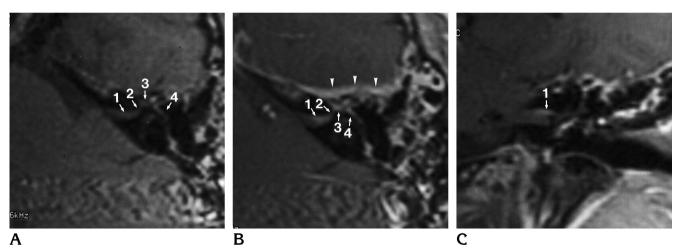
Noncontrast (500/15/2) (*A*) and contrast-enhanced (600/20/4) (*B*) transverse and coronal (*C*) T1-weighted MR images in a patient with delayed posttraumatic peripheral facial nerve palsy without associated fracture of the temporal bone, obtained 7 days after trauma, show moderate enhancement of the distal intrameatal segment (*1*) and minimal enhancement of the labyrinthine segment (*2*). The geniculate ganglion (*3*) and proximal tympanic segment (*4*) are normally enhanced. Intense dural enhancement is seen along the rostral border of the temporal bone, indicating possible microtrauma of both the temporal bone and the adjacent dura (*arrowheads*).
